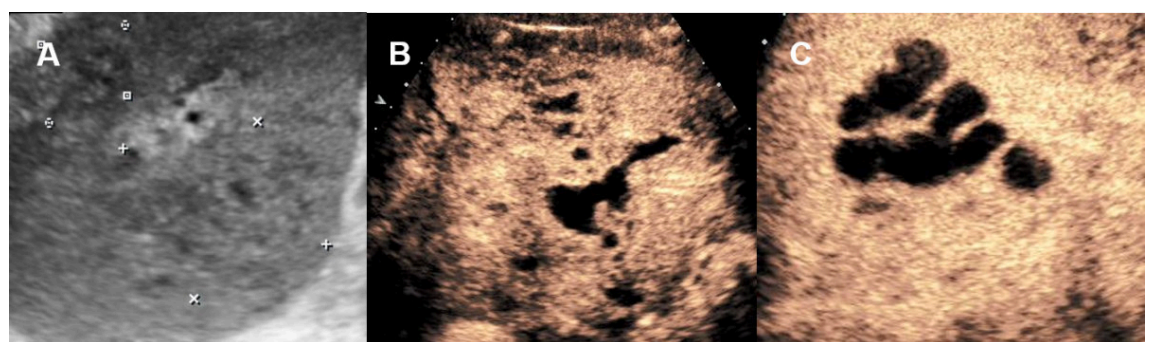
Pyogenic liver abscess on conventional ultrasound and CEUS. A 60-year-old male patient with clinical signs of infection with hardly delimitable hepatic lesions on ultrasound. B, C CEUS with confluent well delimitable liver abscess with anechoic (avascular/necrotic) lined by with surrounding hyperenhancement (hyperaemia).
